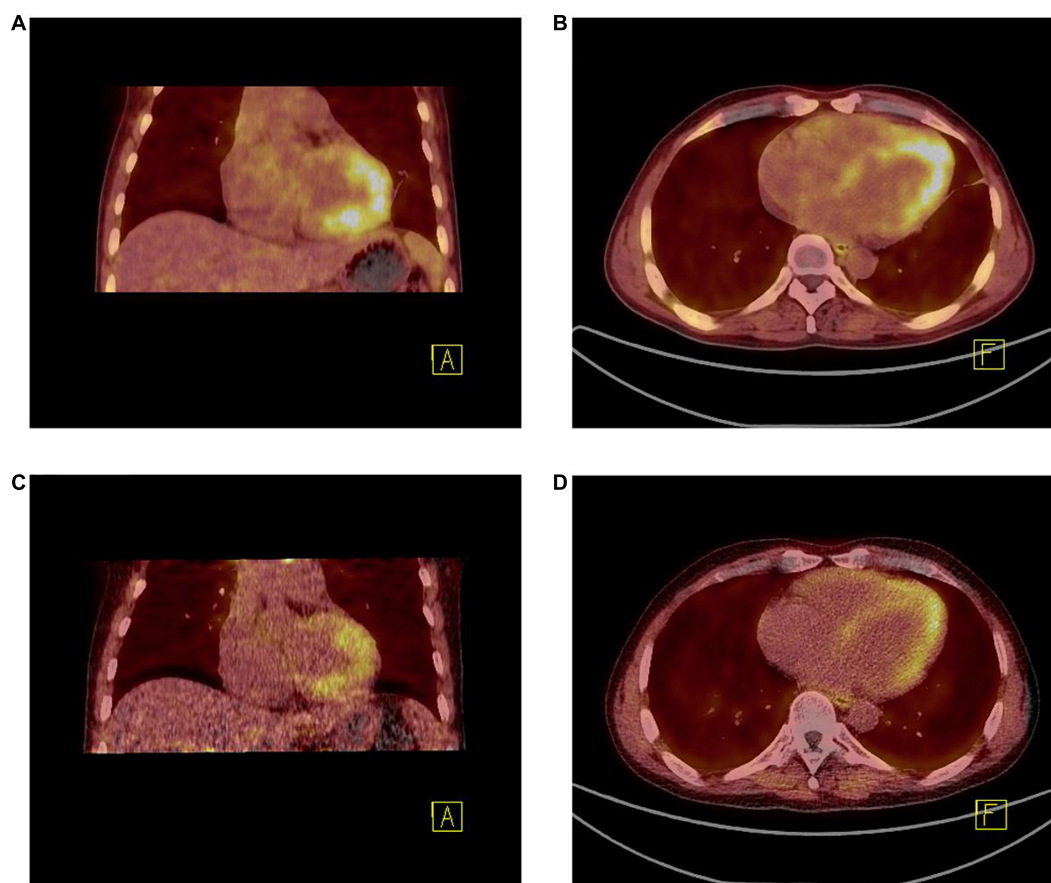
(A,B) 18F-FAPI PET/CT fused image demonstrated the uptake [10.10 (SUVmax), 8.75 (SUVpeak), and 1.92 (SUVmean)] was much higher than that after 2 months of treatment (C,D) [8.40 (SUVmax), 6.91 (SUVpeak), and 1.32 (SUVmean)].
